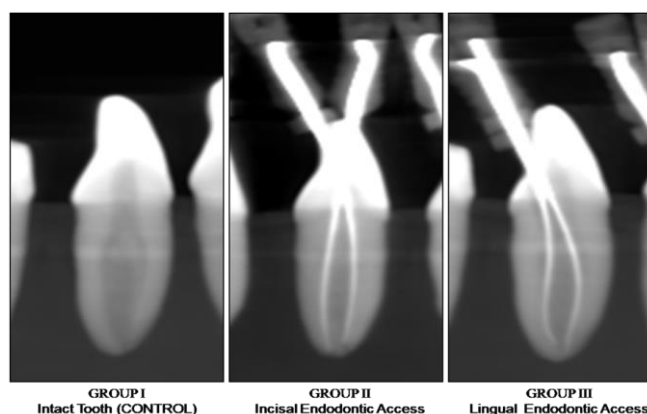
CBCT evaluation of access opening in mandibular incisors.
